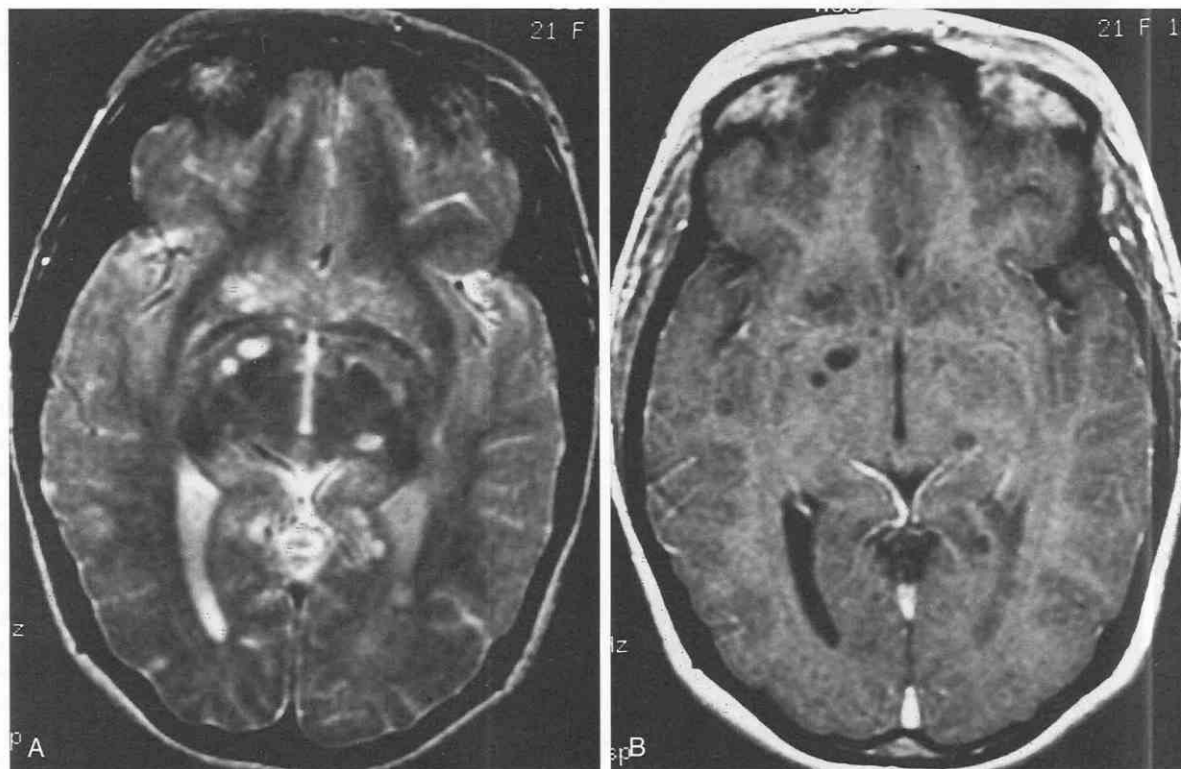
Perivascular space pattern. Axial T2-weighted image (A) and enhanced T1-weighted image (B) show distention of the perivascular spaces at the base of the brain by the gelatinous, nonenhancing pseudocysts of cryptococcosis.
